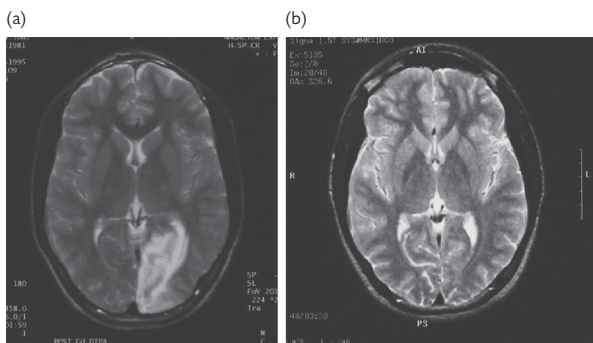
One pattern seen in MELAS is of 'large infarcts', particularly in the occipitoparietal regions and posterior temporal regions. These may not obey arterial boundaries. A typical example is shown in this boy presenting with right homonymous hemianopia in whom left occipital high signal lesion is seen on T2-weighted MRI (a). A characteristic feature of these MELAS 'infarcts' is that remarkable resolution of the MRI abnormalities may occur, as on this repeat scan some months later (b). © Hugh Markus.
